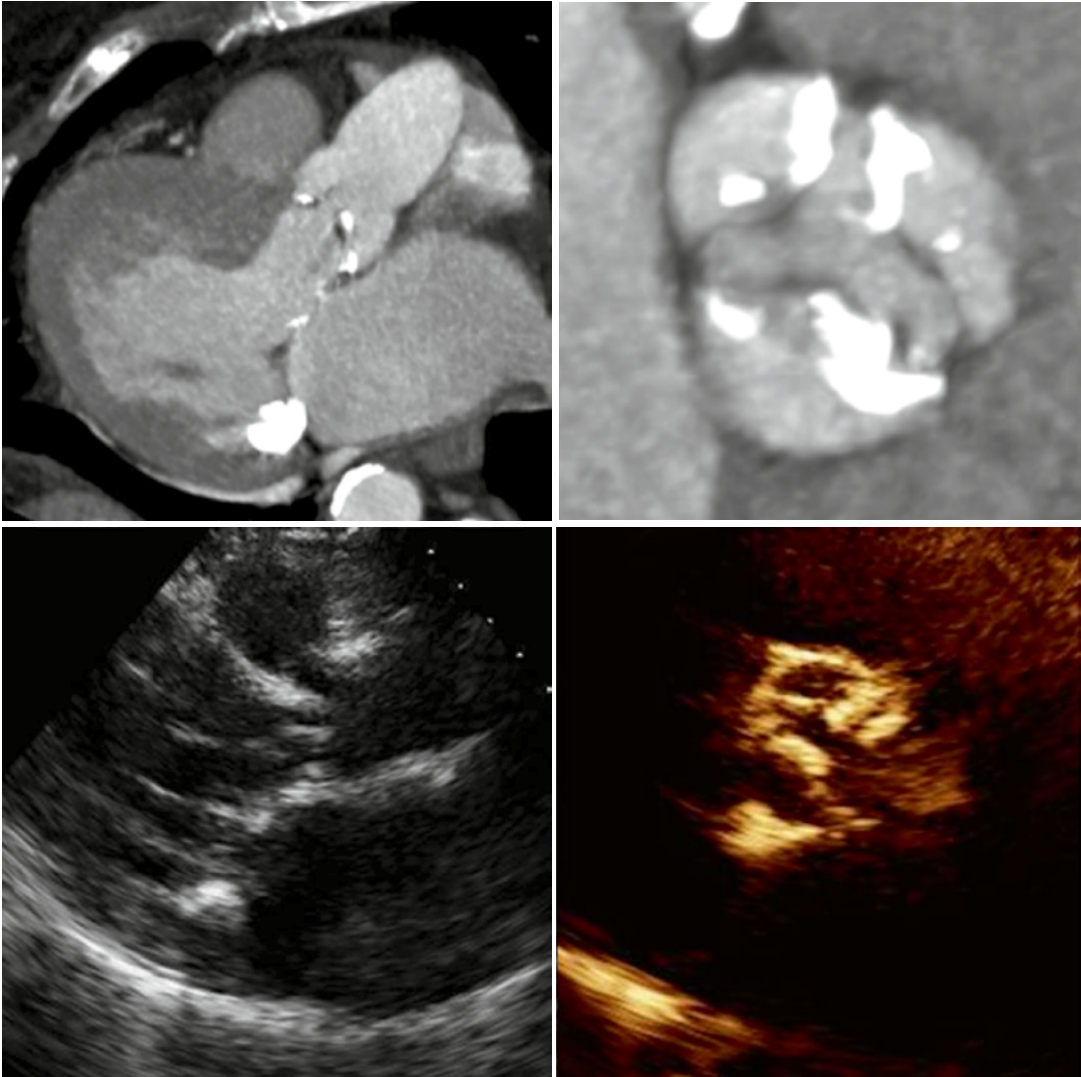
(Above) Double oblique image of left ventricle by CTA (left) and short axis (right) showing the calcified aortic valve. The short axis valve area in systole can be accurately planimeted. (Below) Transthoracic echo
